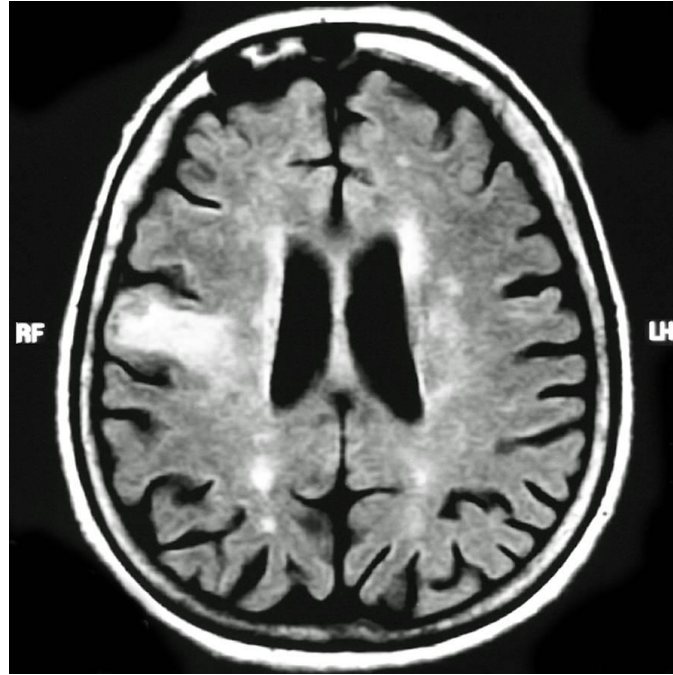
Fluid-attenuated inversion recovery magnetic resonance image of the brain shows increased signal intensity on the right frontal operculum and periventricular white matter and subcortical area.
